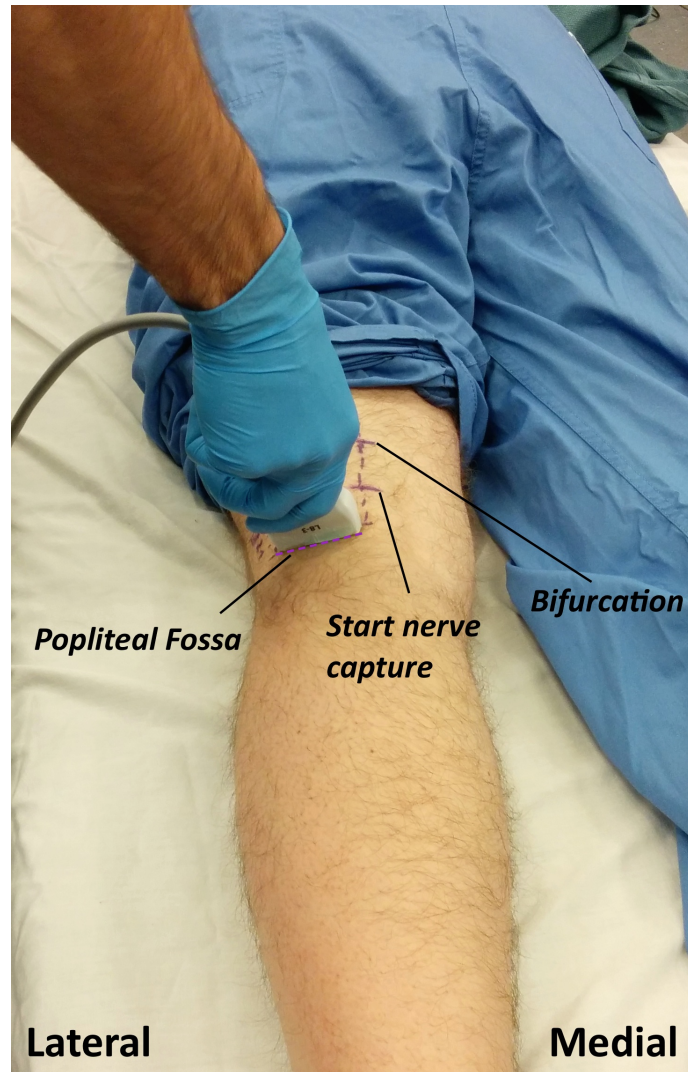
Probe placement for the start of ultrasound guided sciatic nerve block using a traceback approach (posterior) with the patient in a prone position
